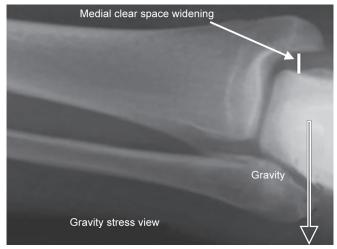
Anteroposterior X-rays demonstrating Weber B fracture of the ankle and widening of medial clear space of > 5 mm indicating deltoid ligament injury (positive gravity stress test)
